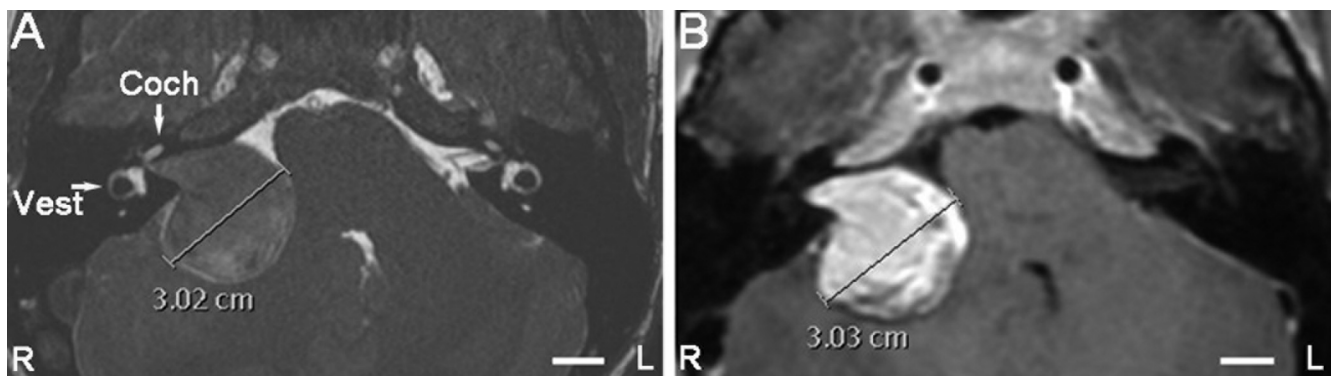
Comparison of non-contrast and gadolinium-contrasted MRI using a 1.5 T machine at a plane showing the maximum diameter of VS in a patient before operation. Both the inner ear fluids and VS was detected with high resolution in non-contrast MRI using 3D-FIESTA sequence (A). Parameters of 3D-FIESTA sequence are as following: TR 5.776 ms, TE 2.184 ms, flip angle 55°, section thickness 0.5 mm, matrix 512 × 512 × 512. VS but not the inner ear fluids was demonstrated in gadolinium-contrast MRI (B). The non-contrast and gadolinium-contrasted MRI detected the tumor at a similar size. Coch: cochlea; L: left; R: right; Vest: vestibule. Scale bar = 1.0 cm.
